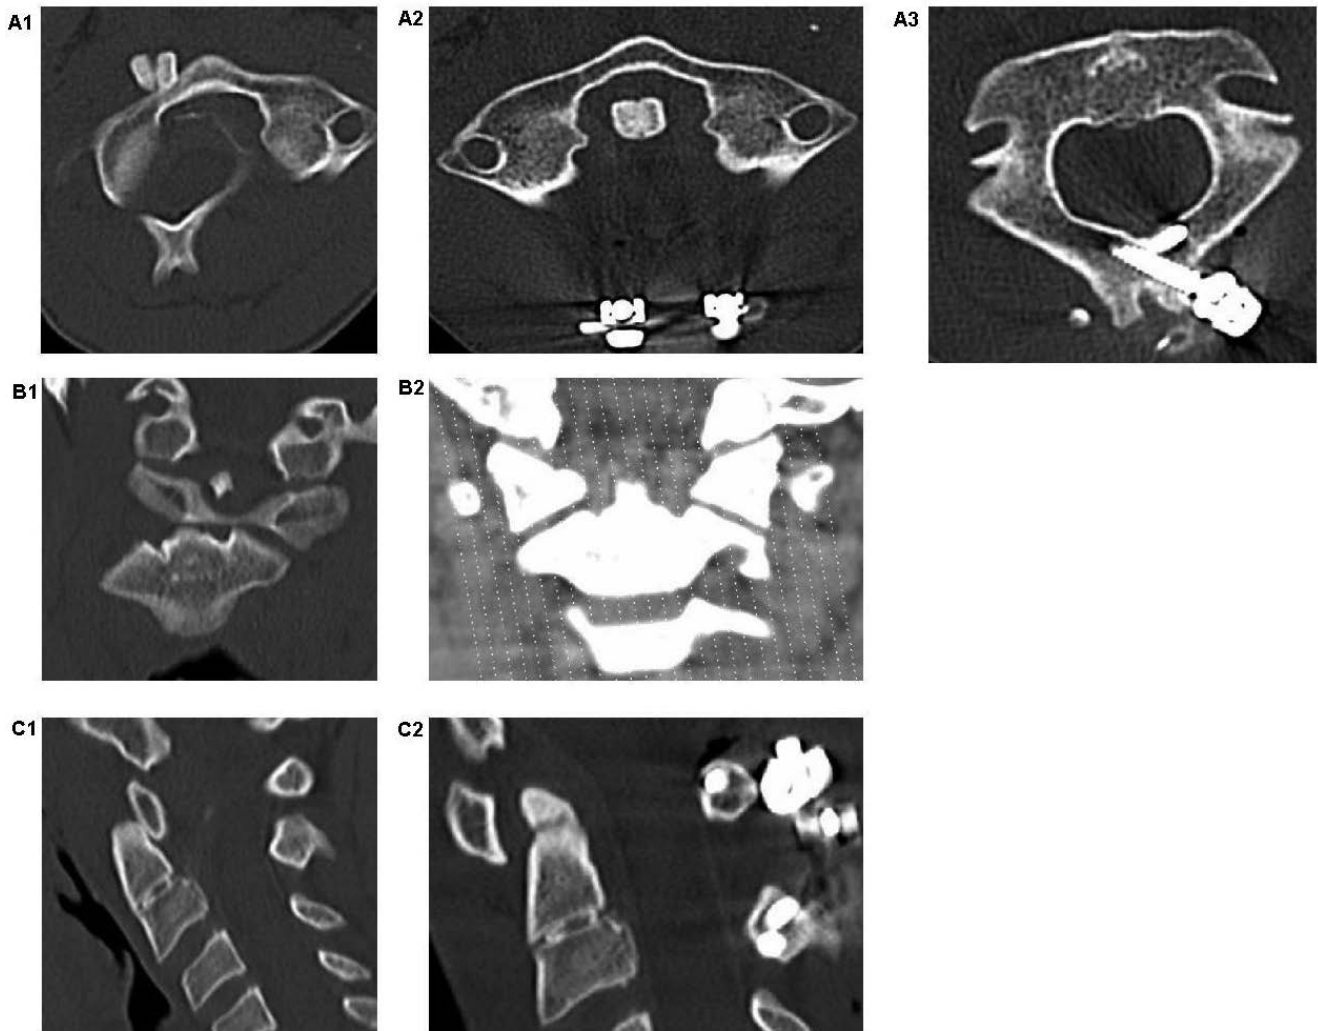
Surgical results of C1/C2 fixation: A1) presurgical; A2 and A3) transversal computed tomography (CT) after dorsal cervical fixation; B) coronal CT before (B1) and after repositioning of C1/C2 (B2); C) sagittal reconstruction of cervical spine before (C1) and after fixation (C2).
